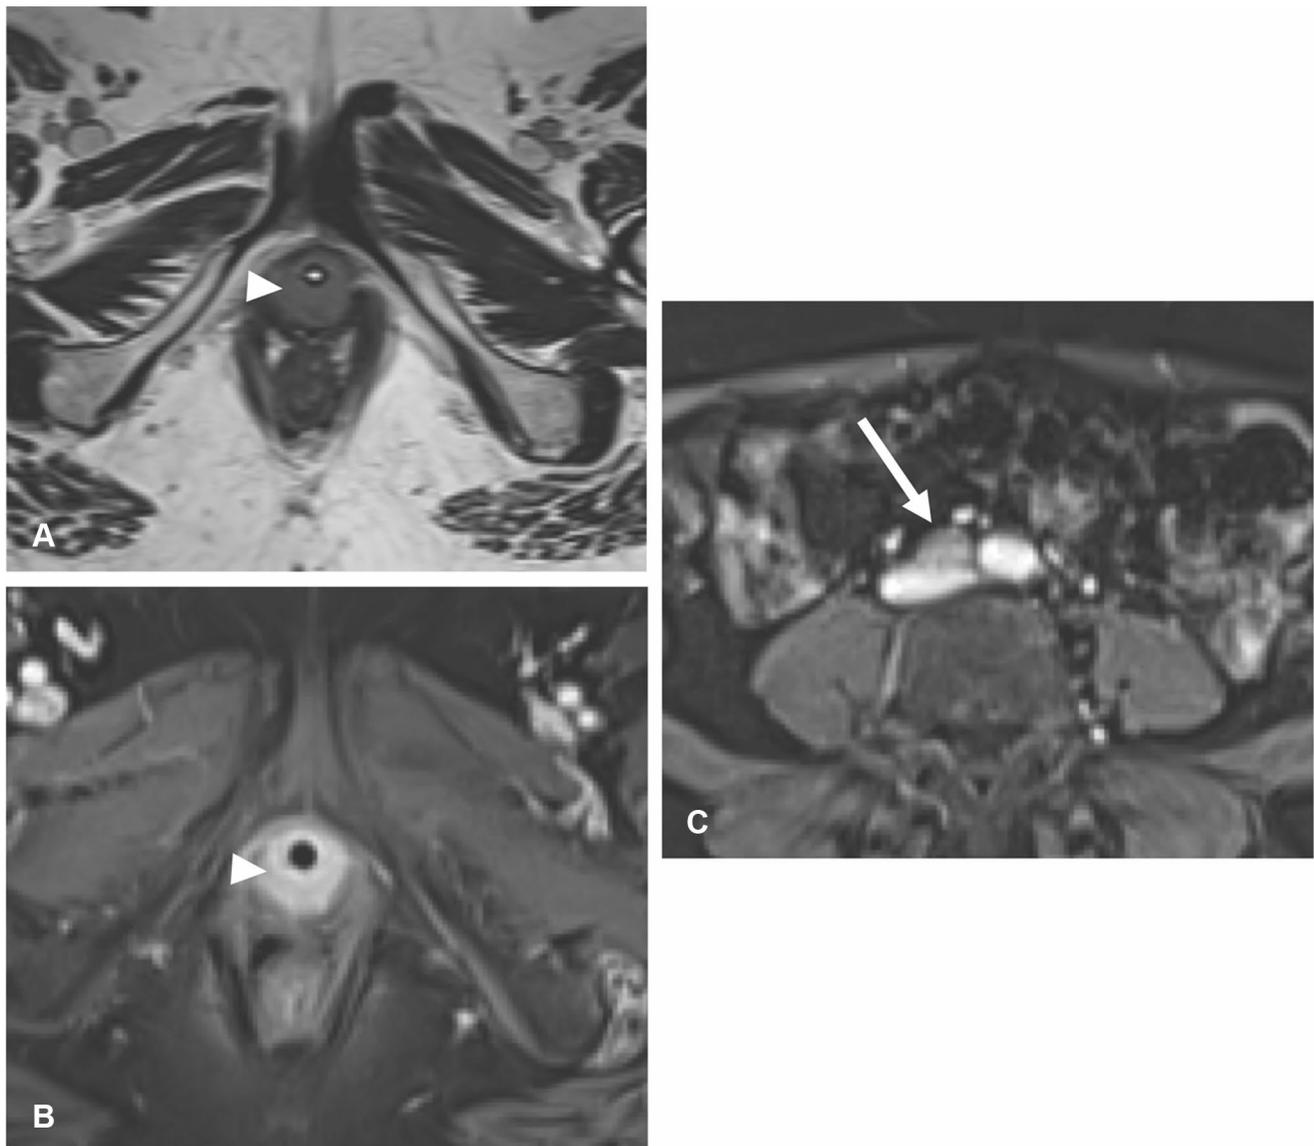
Urothelial carcinoma. A 65-year-old woman with irritative voiding symptoms. a Axial T2WI demonstrates loss of the normal zonal anatomy and intermediate signal tumor (arrowhead)-infiltrating the urethra. b Post-contrast T1-weighted image shows diffuse
